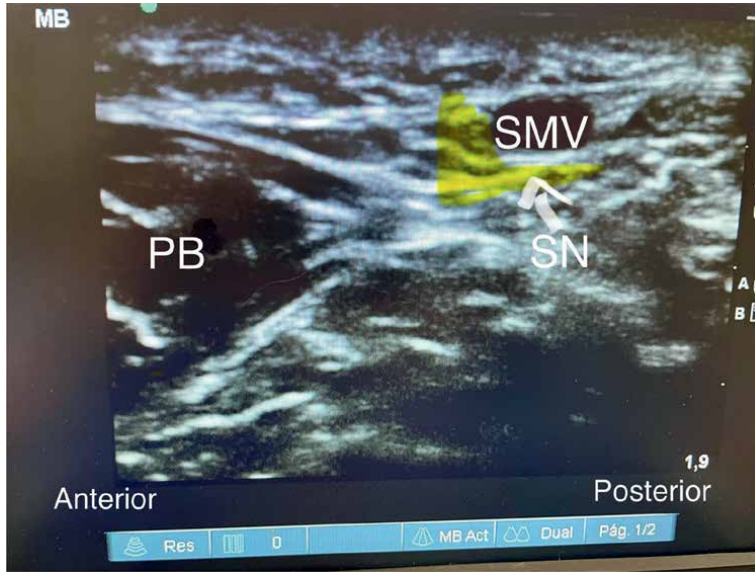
Sonography of the sural nerve (indicated by line arrow). It is accompanied by the lesser saphenous vein, and both are located within the fascia plane (block arrows) between the peroneus brevis (PB) muscle and tendon Achilles (TA). Source: Author.
